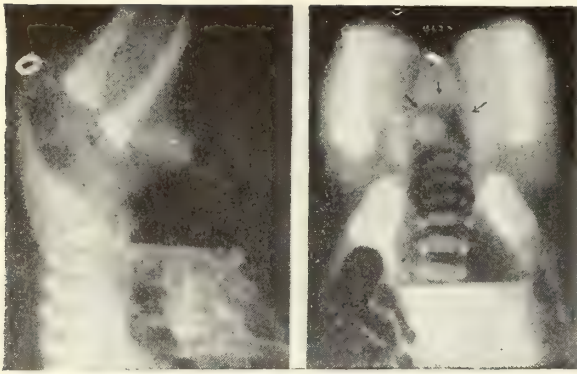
Roentgenograms of child with imperforate anus to show position of the rectal pouch (outlined with arrows) in relationship to anus (marked with an oval piece of lead.) The child is inverted, so that gas will rise and indicate caudal extent of the rectal pouch. (Fig. 114 "Abdominal Surgery of Infancy & Childhood", W. B. Saunders 1947, courtesy Ladd & Gross.)
